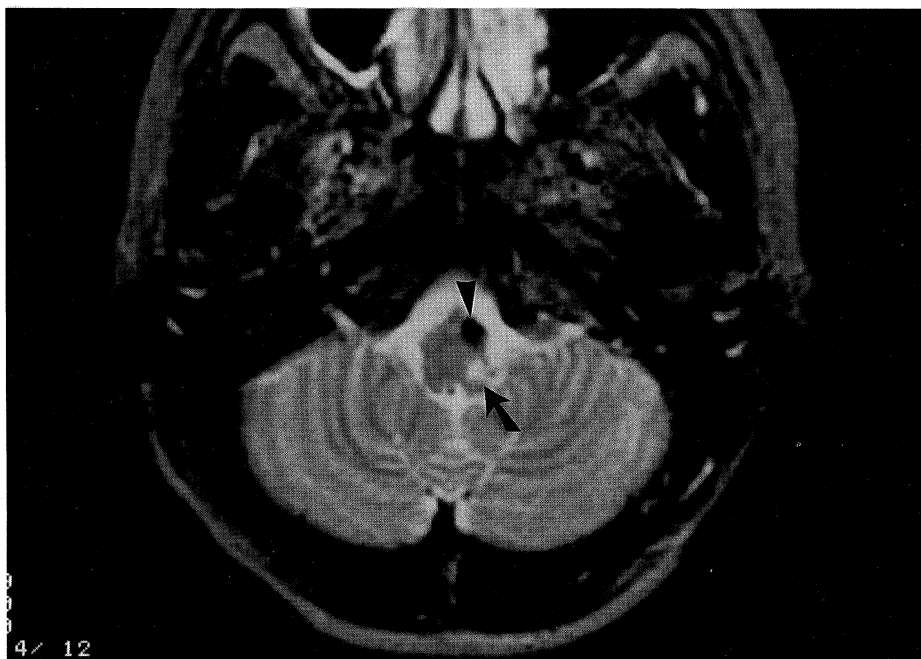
T2-weighted magnetic resonance image showing a small infarction of the left lateral part of the medulla oblongata (arrow) and a dissecting aneurysm of the left vertebral artery (arrowhead).
